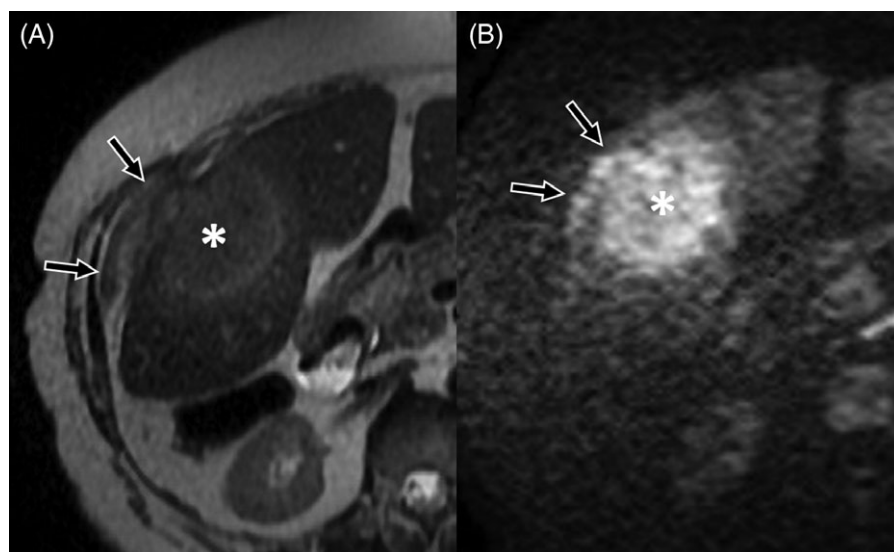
Precontrast initial MRI before therapy. A, Lesion (asterisks) is hyperintense on T2W relative to liver parenchyma and invades the adjacent liver capsule (arrows). B, On diffusion-weighted imaging (DWI) sequences, the lesion shows distinctive restriction of diffusion
